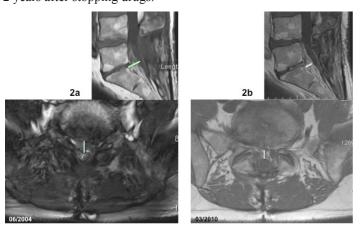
(a,b): Patient 1: Laminectomy for large L5-S1 herniation- (a) postoperative sagittal and axial MRI with left S1 nerve root scar tissue (enhanced after gadolinium injection in T1 sequence) prolonged by hacked fibrotic operative course (arrow); (b) soft tissue fibrotic strong reduction combined with paravertebral muscle regeneration after 4y PENTOCLO treatment.
